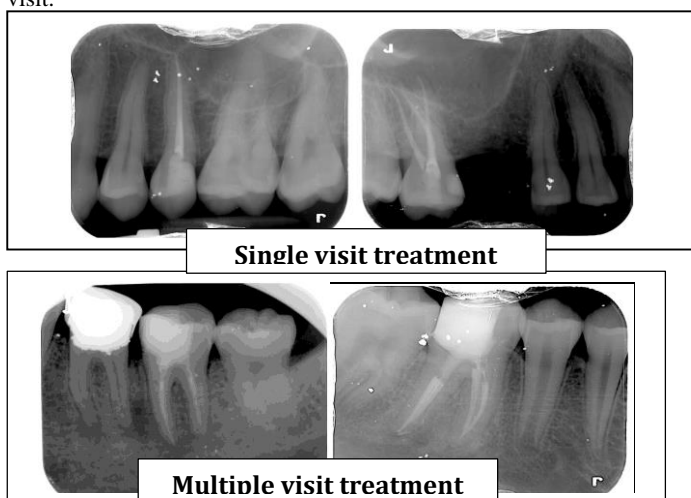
Postoperative radiograph for single and multiple visit treatment.
